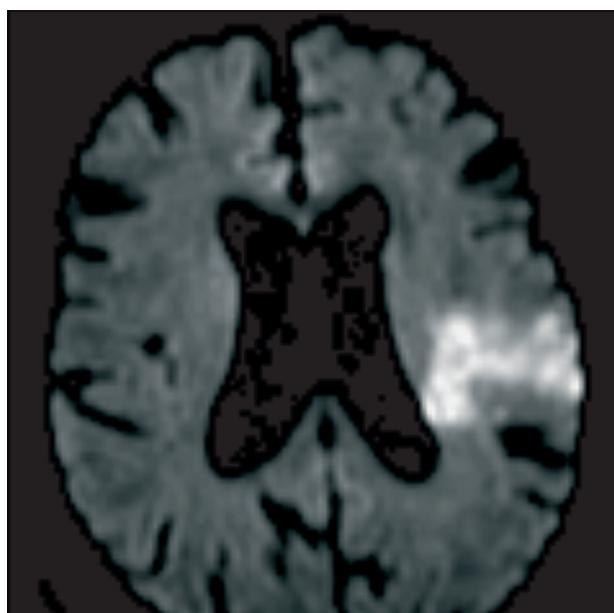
MRI diffusion of CVI
